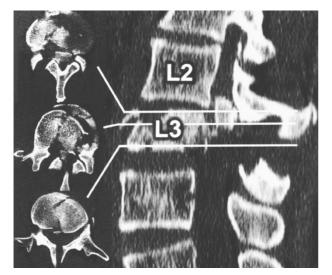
Axial and reformatted CT of the lumbar spine showing the injury of L3. Features include: Anterior (vertebral body) comminution; Retropulsion of a bony fragment into the canal; Lateral translation of L2 on L3 and disruption of the posterior elements with a split spinous process
